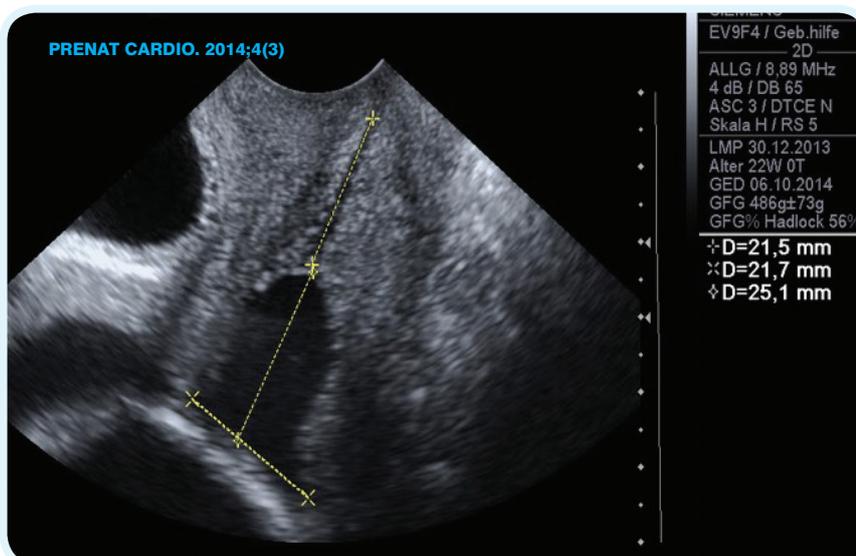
Transvaginal sonography in a twin pregnancy demonstrating with a short cervix and funneling at 22 weeks
